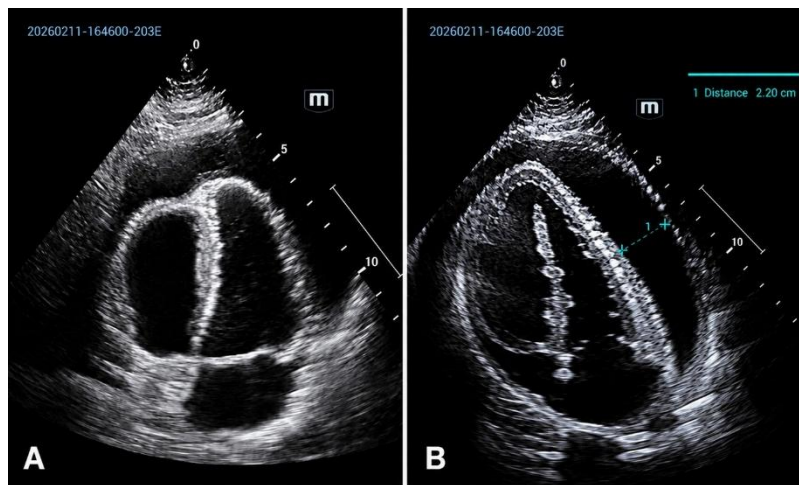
Transthoracic echocardiogram.
